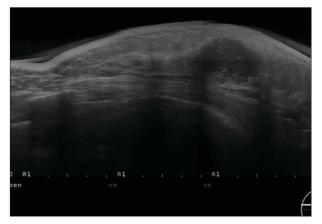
MIP breast ultrasound image, constructed from a 25-mm-thick slab, containing a 3-cm malignant lesion. Calcifications in the cancer are seen clearly.
